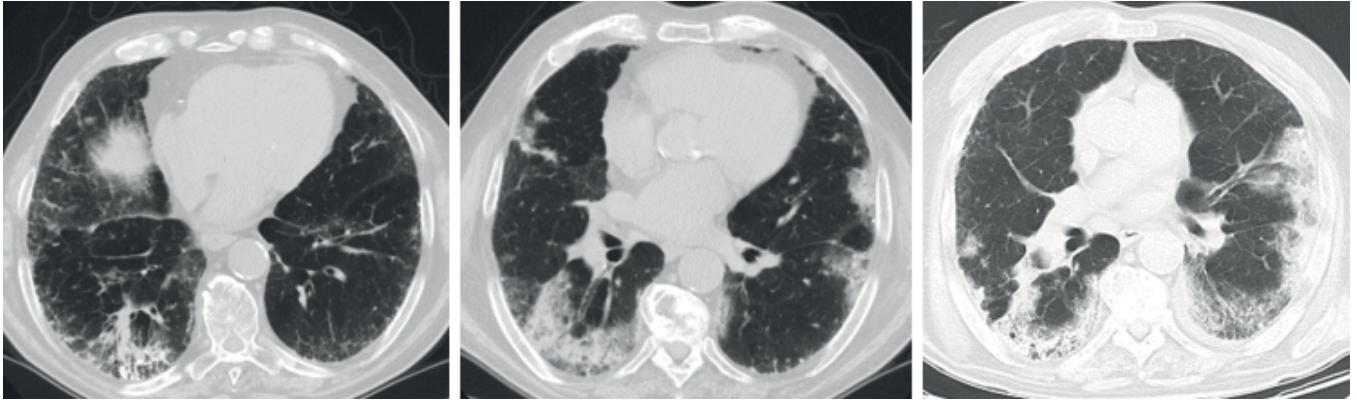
Evolution over 6 months of mucinous adenocarcinoma in a background of usual interstitial pneumonia on chest computed tomography. The cancer looks like consolidation, making early diagnosis challenging.
